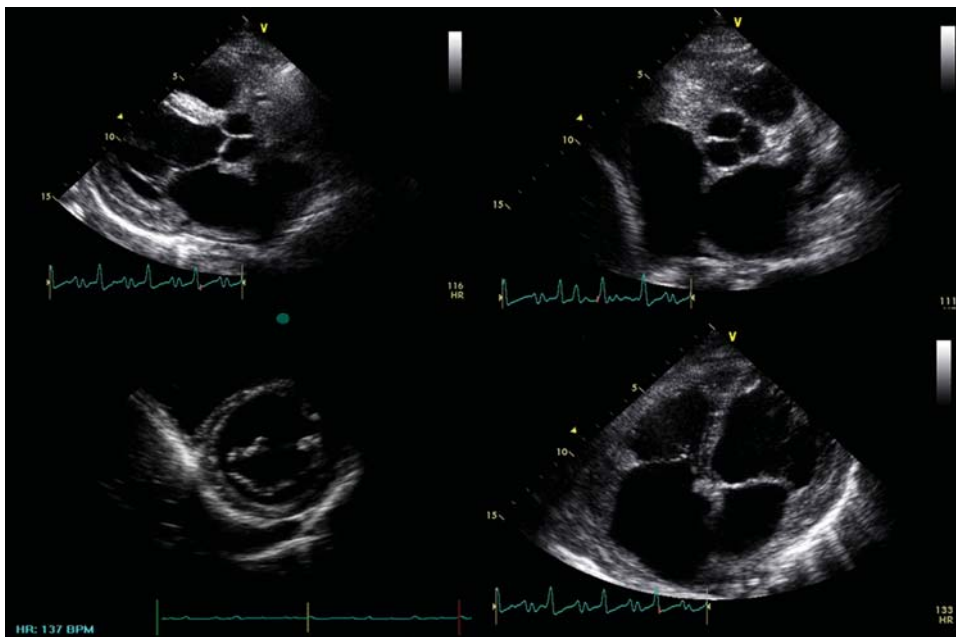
There was marked regression of tumour mass at the echocardiographic examination after 13 days of R-CHOP treatment.
